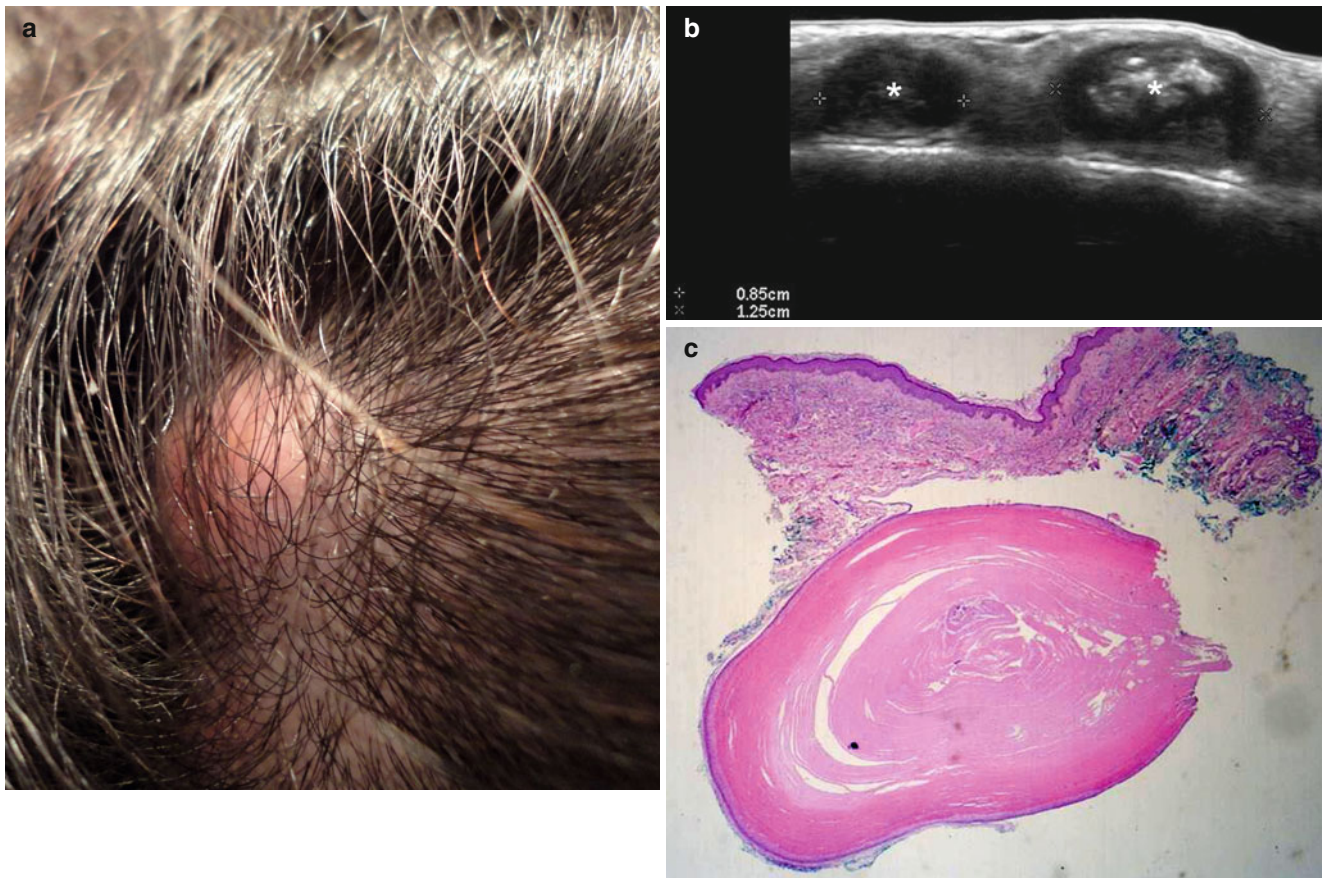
(a–c) Sonographic appearance of trichilemmal cysts. (a) Clinical image shows focal alopecia and erythematous swelling in the scalp. (b) Grey scale ultrasound image (transverse view) demonstrates two adjacent oval-shaped structures (*) in the subcutaneous tissue. There is a 0.85 cm homogeneous hypoechoic cyst in the left side of the figure.
